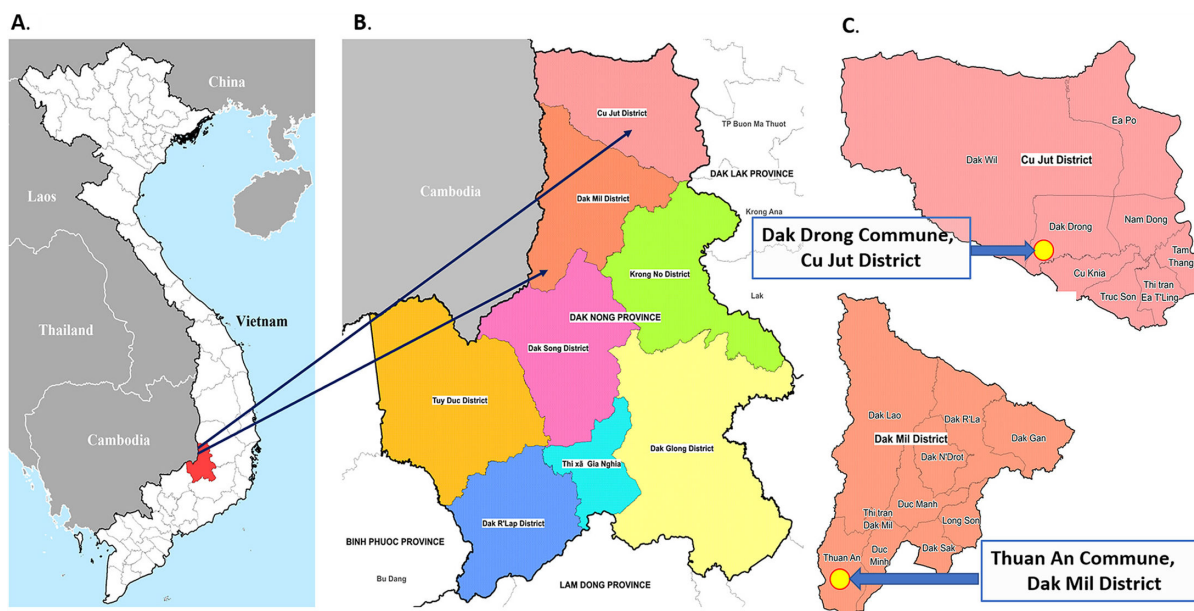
Provincial map of Vietnam with Dak Nong province highlighted in red (A). District map of Dak Nong province (B). Locations of study sites, Dak Drong commune in Cu Jut District, and Thuan An commune in Dak Mil District are indicated by arrows on district maps (C). Map images courtesy of Gerard Kelly, produced using MapInfo Professional v15.0.2 (Pitney Bowes Software Inc. 2015, Stamford, CT) geographic information system mapping software.
